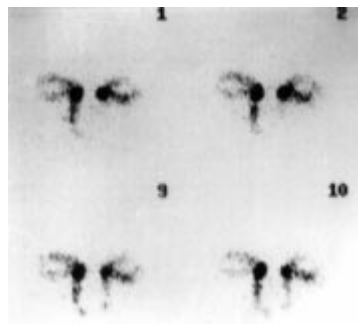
Normal lacrimating scintigram with rapid clearance of tracer in dynamic study (pictures at 10, 20, 90, and 100 seconds).
